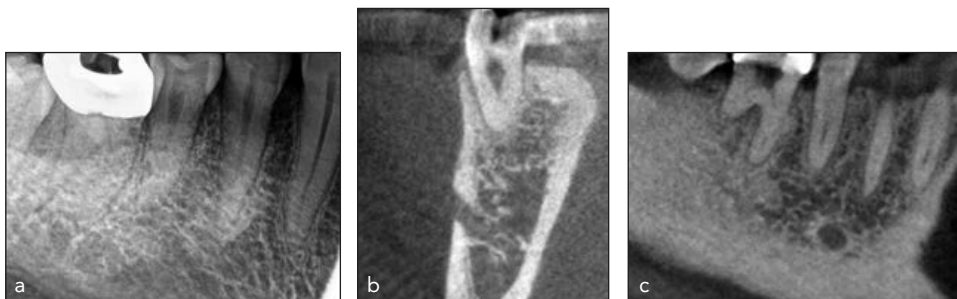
Radiographic depictions of mental foramen between mandibular first and second premolars: (a) periapical radiograph, (b) coronal section of CBCT, and (c) sagittal section of CBCT.
